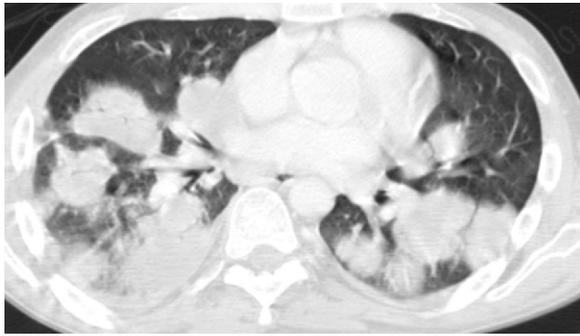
Lymphomatoid granulomatosis in a 68-year-old woman. Axial CT image shows multiple nodular masslike areas of consolidation in the lower lungs as another form of presentation of lymphomatoid granulomatosis. Also noted is right hilar and subcarinal lymphadenopathy. A right pleural effusion is also present.
